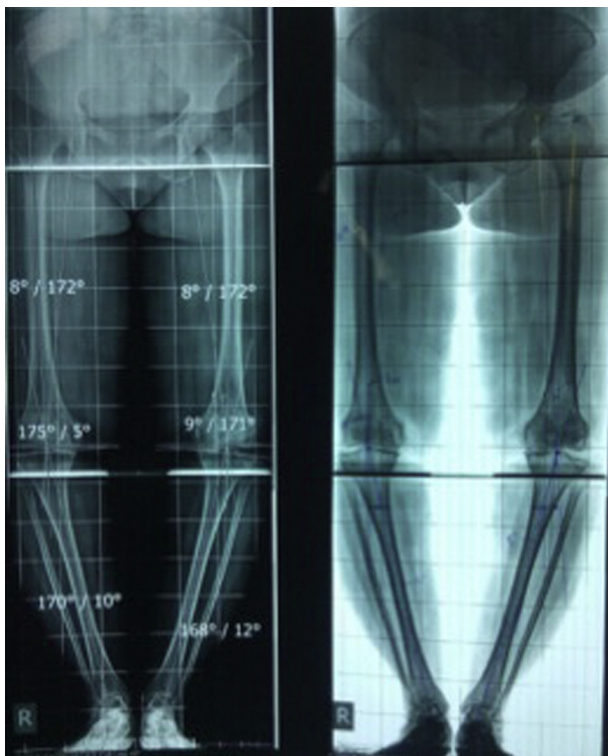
Standing AP radiograph of the lower limbs to determine femoro-tibial angle.
